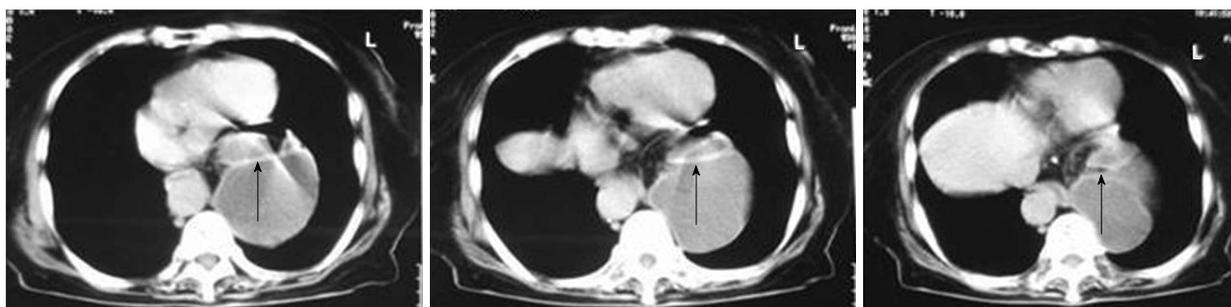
Abdominal computed tomography scan. An incarcerated upper gastrointestinal tract in the thoracic cavity (arrows). The gastrointestinal tract dislocated in the thoracic cavity was significantly dilated, where fluid had accumulated.
